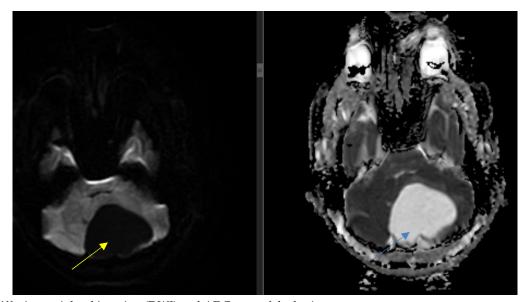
Axial diffusion weighted imaging (DWI) and ADC map of the brain
